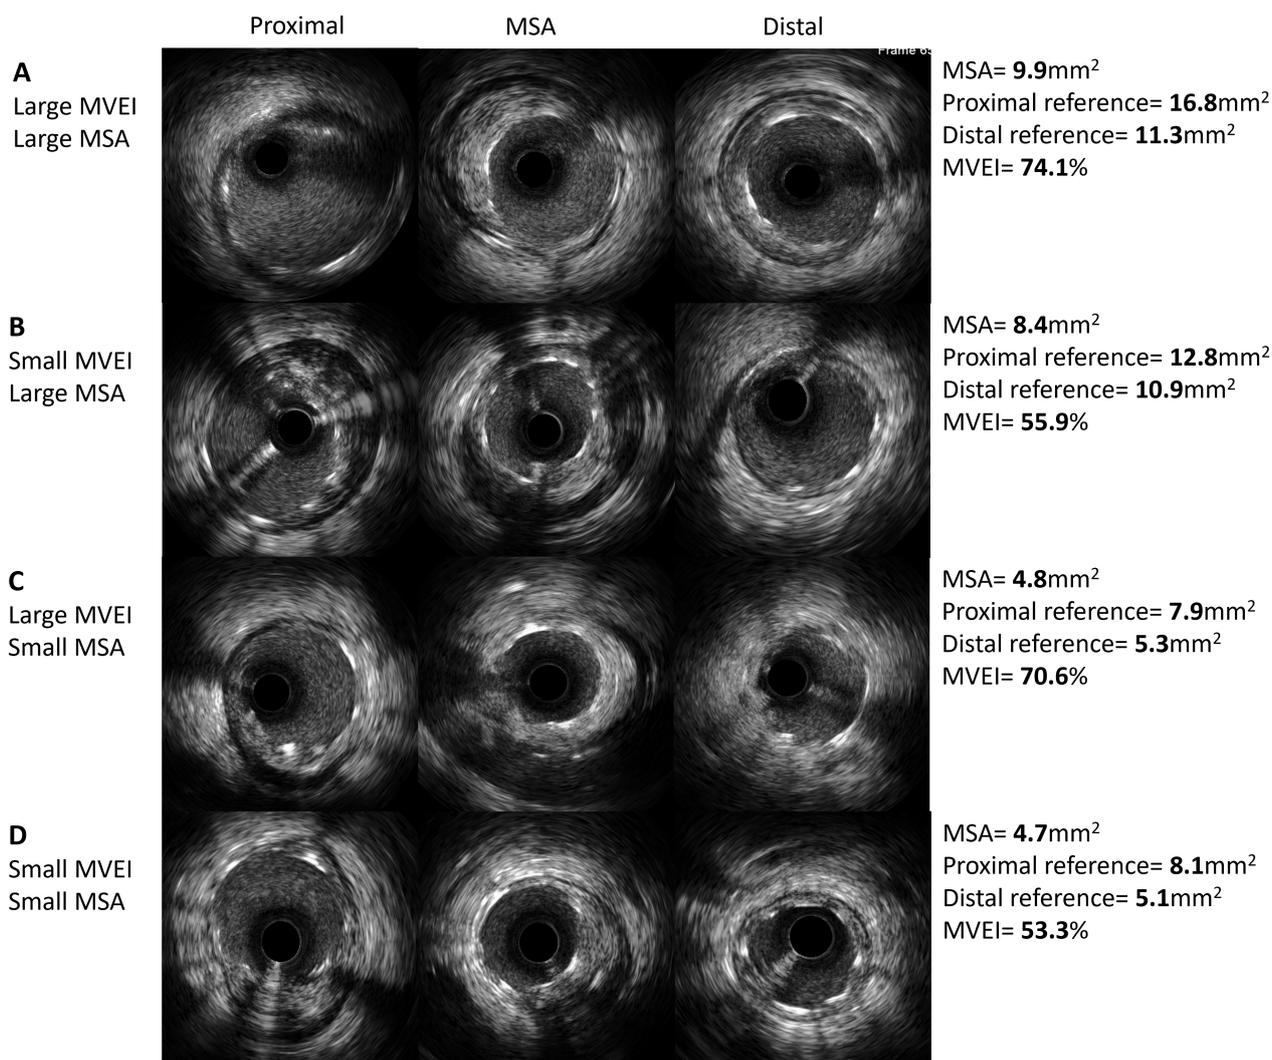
Representative IVUS images with different patterns of MVEI. (A) Both MSA and MVEI are large. (B) MSA is large and MVEI is small. (C) MSA is small and MVEI is large. (D) Both MSA and MVEI are small. MVEI, minimal volumetric expansion index; IVUS, intravascular ultrasound; MSA, minimal stent area.
